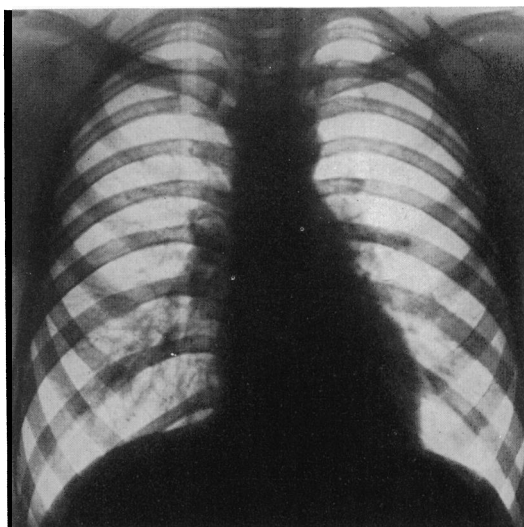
X-ray of chest eight weeks after admission to hospital.
